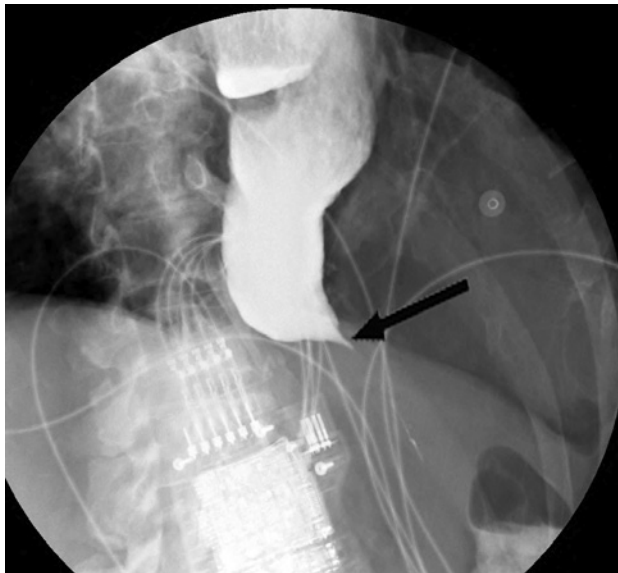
Upper gastrointestinal radiograph showing a parrot beak deformity.
